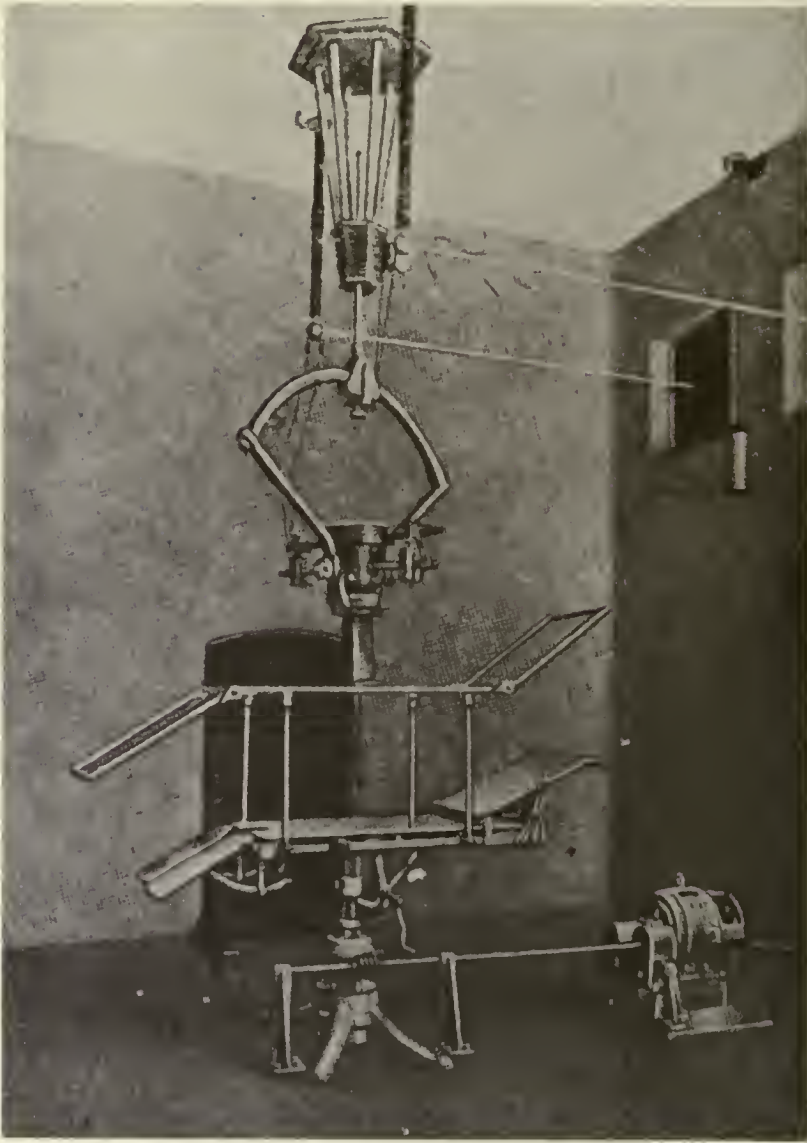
Rotation therapy with an X-ray tube as described by Hirsch and Holzkecht in 1925.
